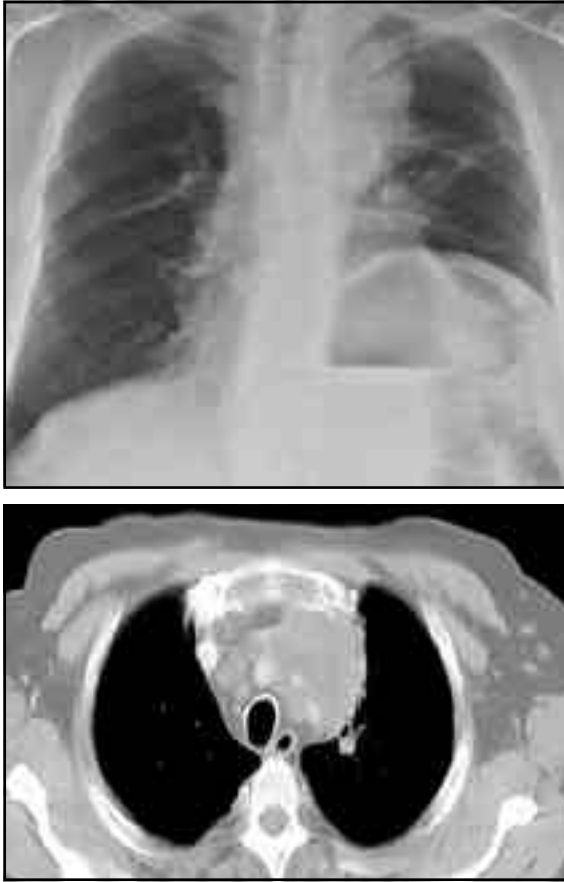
a-b. A mass invading mediastinum in left lung in chest X-ray and thorax CT relapse of SCLC (September 2006)
